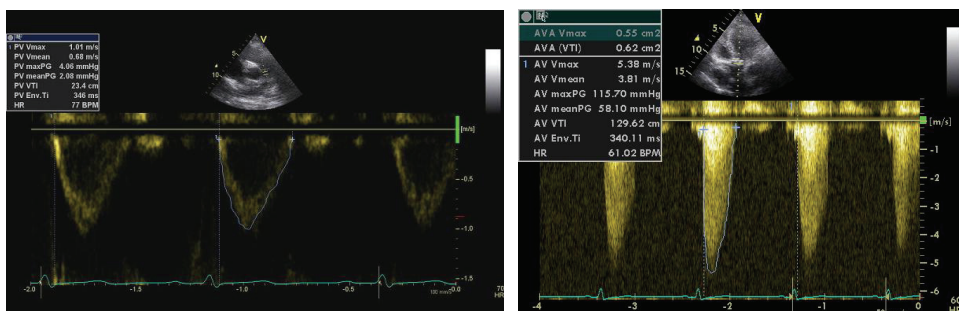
The velocities are variable with time. Amplitude is shown as brightness; velocity is shown on the y-axis and time on the x-axis. This results in the typical Doppler flow velocity curves. Left figure: Normal pulmonary artery blood flow assessed by pw Doppler and right figure: maximal velocity through a stenotic aortic valve assessed by cw Doppler.
